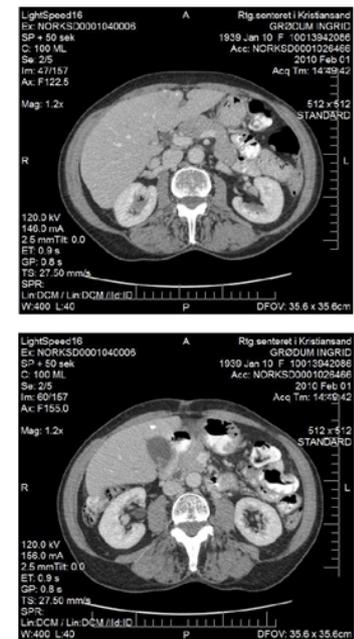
(b): Massive liver metastases on CT scan abdominal CT scan after 7 months of treatment.
